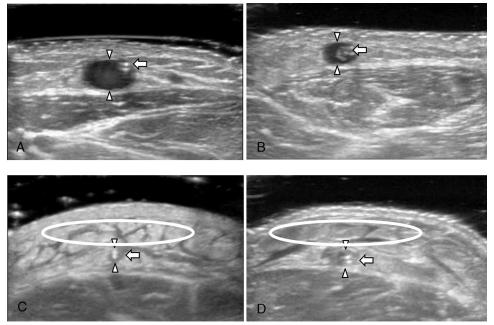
Typical ultrasonography features: A, no etiologies; B, only thrombus; C, only subcutaneous edema; and D, thrombus with subcutaneous edema. A transverse scan shows the oval shape of the vessel wall (see arrowheads). The high echo spots show the SPC tips (arrows). The mild high echo spots in the vein show partial occlusion of a vein by thrombus. The area surrounding the vein with the SPC tip appeared as edema of the subcutaneous fat layer (circles). *Abbreviation: SPC, short peripheral catheter.*
